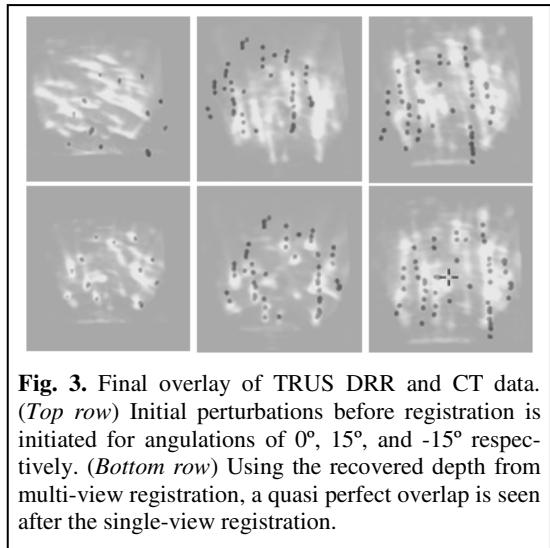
Final overlay of TRUS DRR and CT data. (*Top row*) Initial perturbations before registration is initiated for angulations of 0° , 15° , and -15° respectively. (*Bottom row*) Using the recovered depth from multi-view registration, a quasi perfect overlap is seen after the single-view registration.
